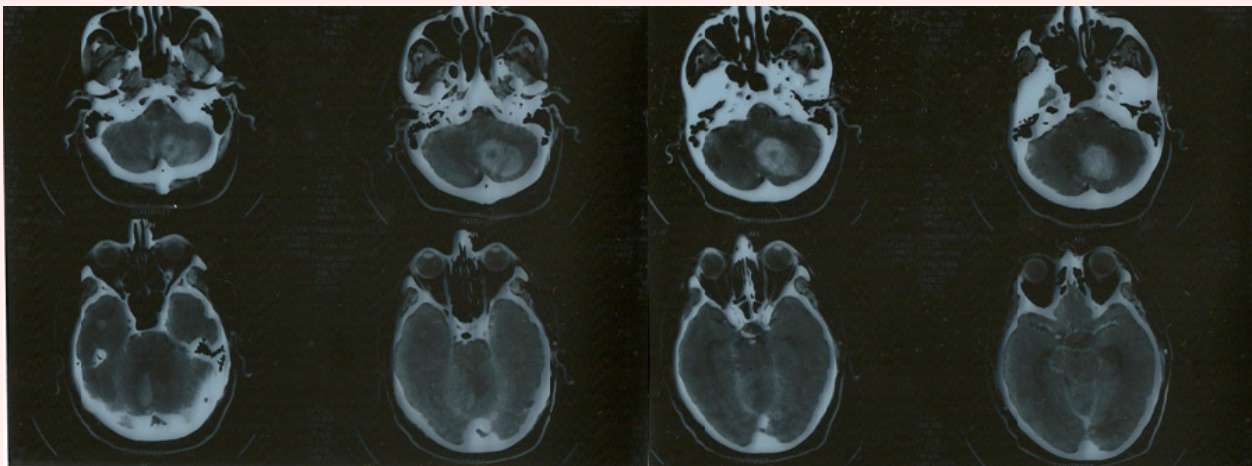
The brain contrast CT scan performed 24 hours after admission revealed multiple zones with contrast enhancement localized in both cerebellar hemispheres, in the right temporal lobe, in the right occipital lobe and in the left occipital lobe, one of them associated with an acute hemorrhage (a left cerebellar hematoma). The aspect of the lesions was suggestive for cerebral metastases.
